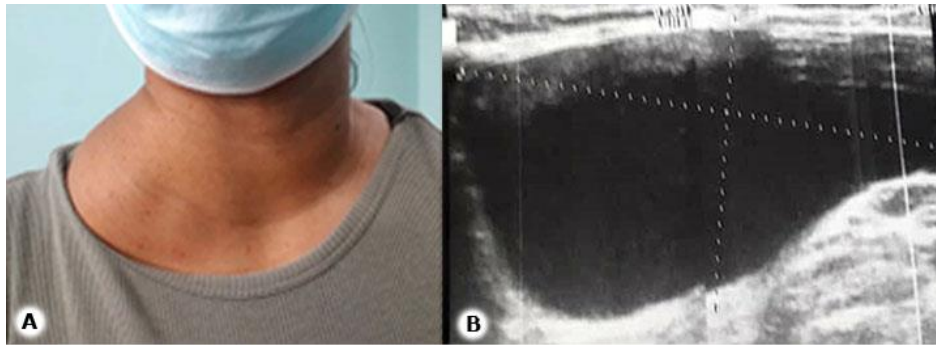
A-Right cervico-lateral mass of approximately 8 cm. B- Sonographic image.
